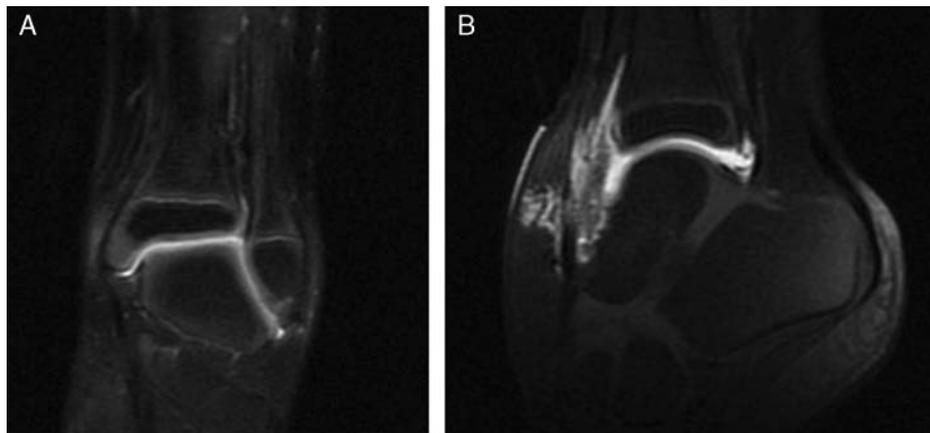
A and B, A MRI taken 10 months after injury. There appears to be thick uninjured talar cartilage with no underlying osseous edema on the coronal and sagittal sections of this T2-weighted scan.
